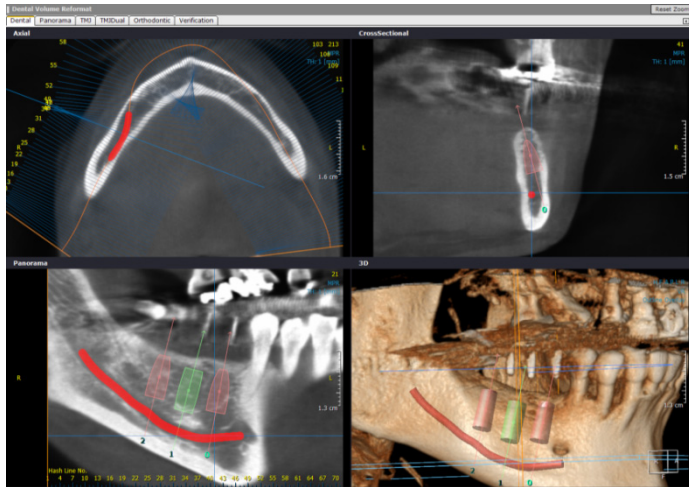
Example of preparing a radiographic template with gutta percha cylinders to integrate the information on preferred implant axis and implant position, biomechanics and esthetics with consideration to anatomic restrictions. The mandibular nerve has been visualised (Ondemand 3D screenshot of Scanora 3D dataset) to allow interactive planning of implant placement without hitting this canal. Courtesy of Filip Van de Velde, periodontologist, Antwerp Belgium
